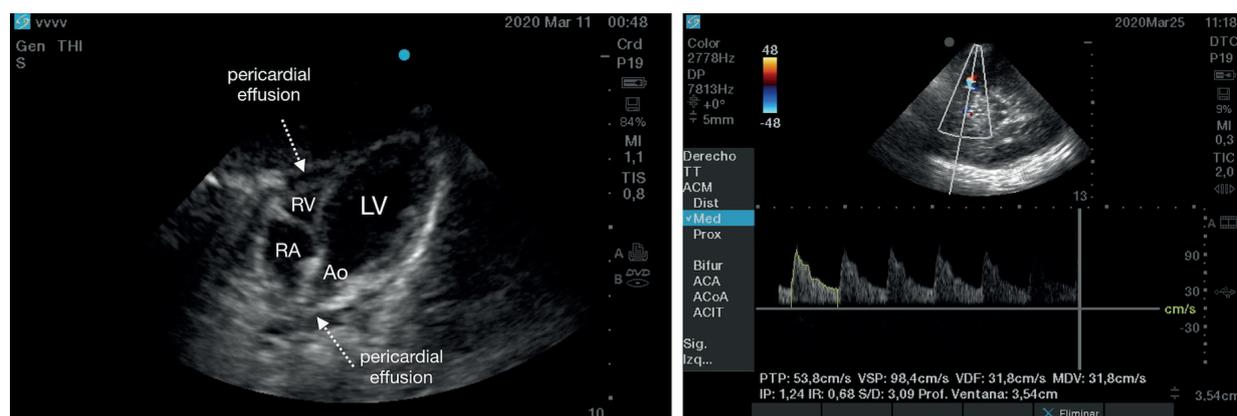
Left:* Pericardial effusion (subcostal axis); *Right:* Transcranial doppler for assessing brain flow status. Ao: aortic chamber; RA: right atrium; RV: right ventricle; LV: left ventricle.
